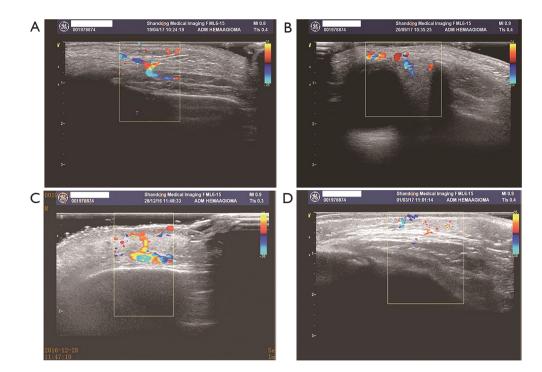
Ultrasonic examination results of case 2. (A) Before starting propranolol therapy, at 1-month, IH was about 0.91 cm thick on the left forehead region, and the blood flow signals accounted for 30% of the whole mass area. The size of lower echoic area was about 1.9 cm \times 0.9 cm on the left orbital region and the blood flow signals accounted for 30% of the whole mass area; (B) before starting prednisone therapy, at 5-month, IH was about 0.53 cm thick on the left forehead region, and the blood flow signals accounted for 20% of the whole mass area. The size of lower echoic area was about 1.4 cm \times 0.57 cm on the left orbital region, and the blood flow signals accounted for 20% of the whole mass area; (C) at 6-month after prednisone therapy for 1 month and continuing oral propranolol and topical timolol solution, IH was about 0.53 cm thick on the left forehead region, and the blood flow signals accounted for 10% of the whole mass area. IH was about 0.53 cm thick on the left orbital region, and the blood flow signals accounted for 10-20% of the whole mass area. IH was about 0.53 cm thick on the left forehead region, and the blood flow signals accounted for 10-20% of the whole mass area. IH was about 0.53 cm thick on the left forehead region, and the blood flow signals accounted for 10% of the whole mass area. IH was about 0.53 cm thick on the left forehead region, the blood flow signals accounted for 10% of the whole mass area. The size of the lower echoic area was about 0.82 cm \times 0.67 cm on the left orbital region, and the blood flow signals accounted for 10-15% of the whole mass area.
